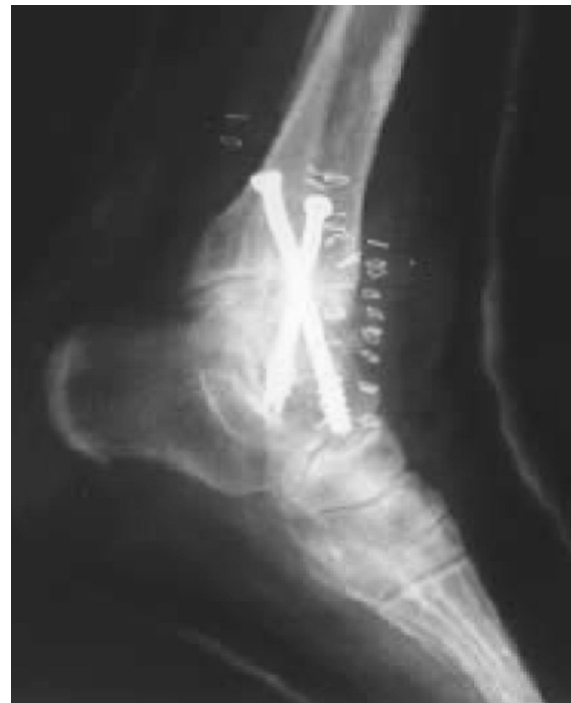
Lateral weightbearing ankle x-ray, immediate post operative film.
